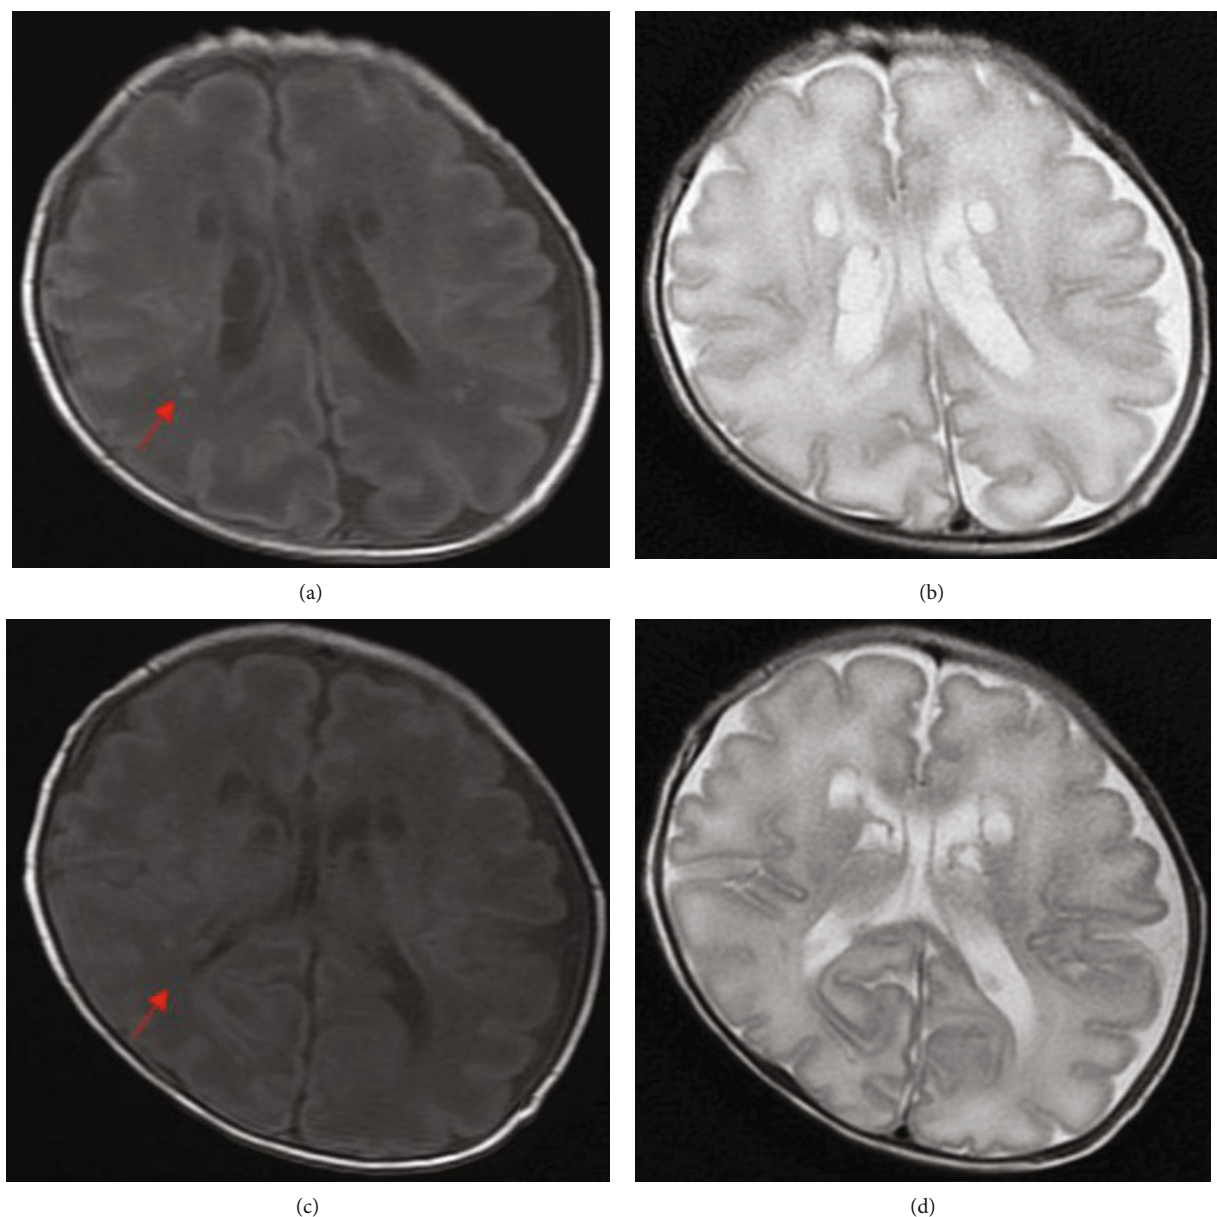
MRI imaging before and after subhypothermia treatment. (a) T1W1 on MRI before treatment; (b) T2W1 on MRI before treatment; (c) T1W1 on MRI 2 weeks after subhypothermia treatment; (d) T2W1 on MRI 2 weeks after subhypothermia treatment. After 2 weeks of subhypothermia treatment, the speckled high signal next to the posterior horn of the bilateral ventricles was significantly reduced; see red arrow.
